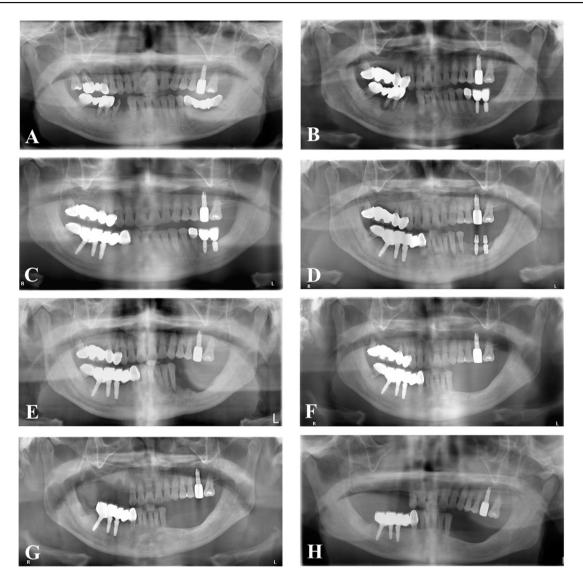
A series of panoramic radiographs of our patients with the medication-related osteonecrosis of the jaw (MRONJ). (A) The panoramic radiograph taken at the time when the patient visited the local dental clinic for the first time for the toothache of tooth 45 at the age of 60, demonstrating his original teeth and jawbone condition. (B) Panoramic radiograph taken at the time when the patient was 64 years old, showing the teeth 14 to 18 having been replaced by a new dental bridge and the teeth 36 and 37 having been replaced by the dental implants, while the condition of the right mandibular posterior teeth in a state of gradual deterioration. (C) Panoramic radiograph taken at the time when the patient was suffering from the toothache and mobility of tooth 35 at the age of 66, revealing the periodontal ligament widening of tooth 35 and the teeth 43 to 48 having been replaced by a new dental bridge combined with the dental implants. According to the patient's statement, he was diagnosed as having the prostate cancer and was treated by injection of Xgeva (denosumab) once per month due to the prostate cancer bone metastasis. The local dentist recommended the extraction of affected tooth 35 six months after the last injection of denosumab. (D) Panoramic radiograph taken at the time when the patient's tooth 35 was extracted (in the dental clinic) 6 months later, showing that the socket of tooth 35 and the jawbone of the dental implants of teeth 36 and 37 area still did not heal, and the MRONJ was diagnosed. (E) Panoramic radiograph taken at the time when the patient completed the treatment of sequestrectomy at the posterior area of the left mandible and the removal of the dental implants of teeth 36 and 37 (in the hospital), showing the well-healed operation site at the posterior edentulous area of the left mandible in the early postoperative period. (F) Panoramic radiograph taken at the time two years after the sequestrectomy was performed, indicating a good clinical outcome of the operation site at the posterior edentulous area of the left mandible, while the periodontal condition of the right maxillary posterior teeth in a state of gradual deterioration. (G) Panoramic radiograph taken at the time when the patient completed the treatments of extraction of teeth 14, 15 and 18 and alveolar bone debridement at the corresponding area, showing the well-healed operation site at the posterior edentulous area of the right maxilla in the early postoperative period. (H) Panoramic radiograph taken at the time 4.5 years after the sequestrectomy was performed and 2.5 years after the right maxillary posterior teeth were extracted, indicating a good clinical outcome of the operation sites at the posterior edentulous area of the left mandible and at the posterior edentulous area of the right maxilla.
